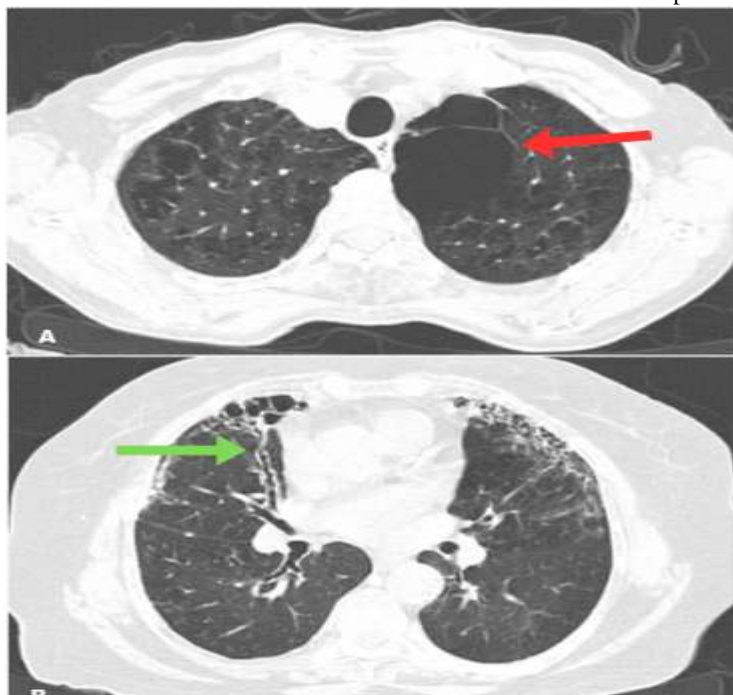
Chest computed tomography with high resolution showing quantitative data in a COPD patient. A: Centrilobular emphysema (red arrow). B: Bronchiectasis (green arrow)
